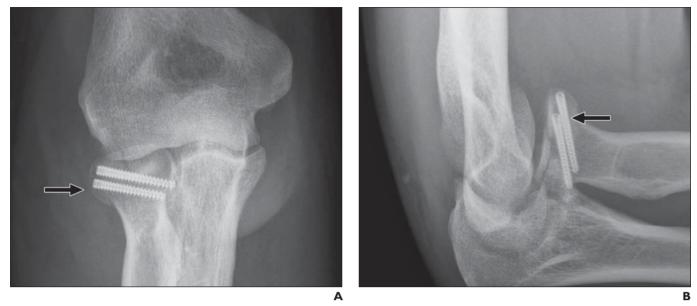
45-year-old man with radial head fracture. A and B, Anteroposterior (A) and lateral (B) radiographs show two screws (Acutrak Mini, Acumed) (*arrow*) fixating intraarticular fracture of radial head.
